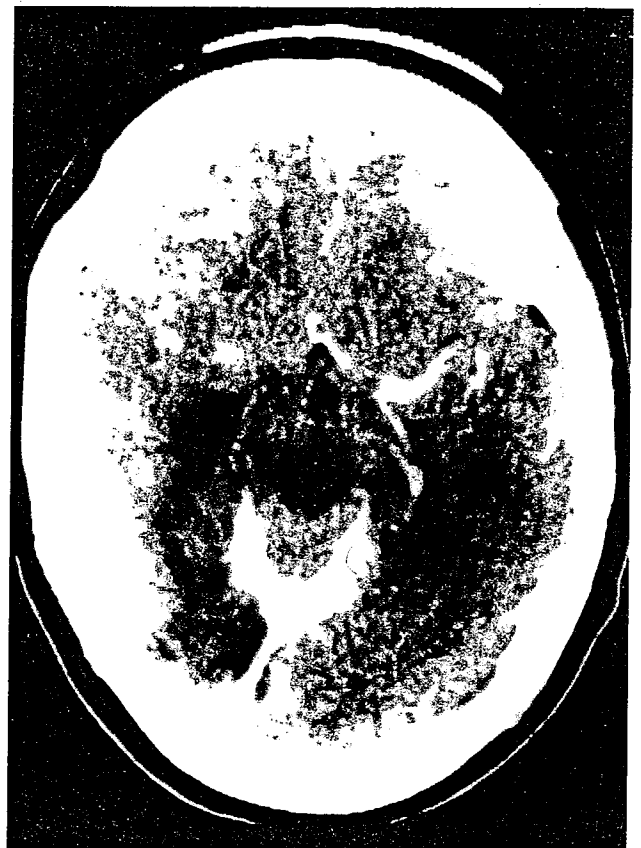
CT-scan obtained 8 months after the operation demonstrating the complete resolution of the ependymitis as well as the abscess.
